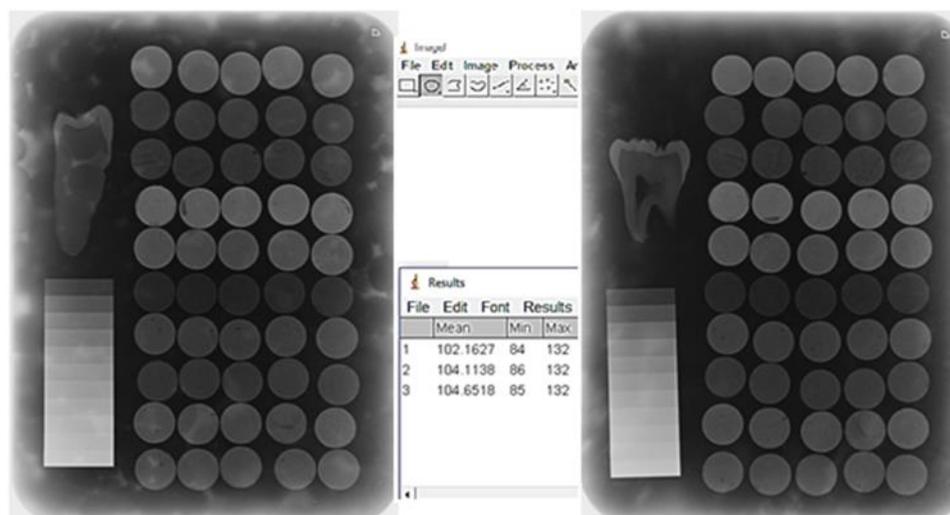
Converting radiography to numeric data with image J program
